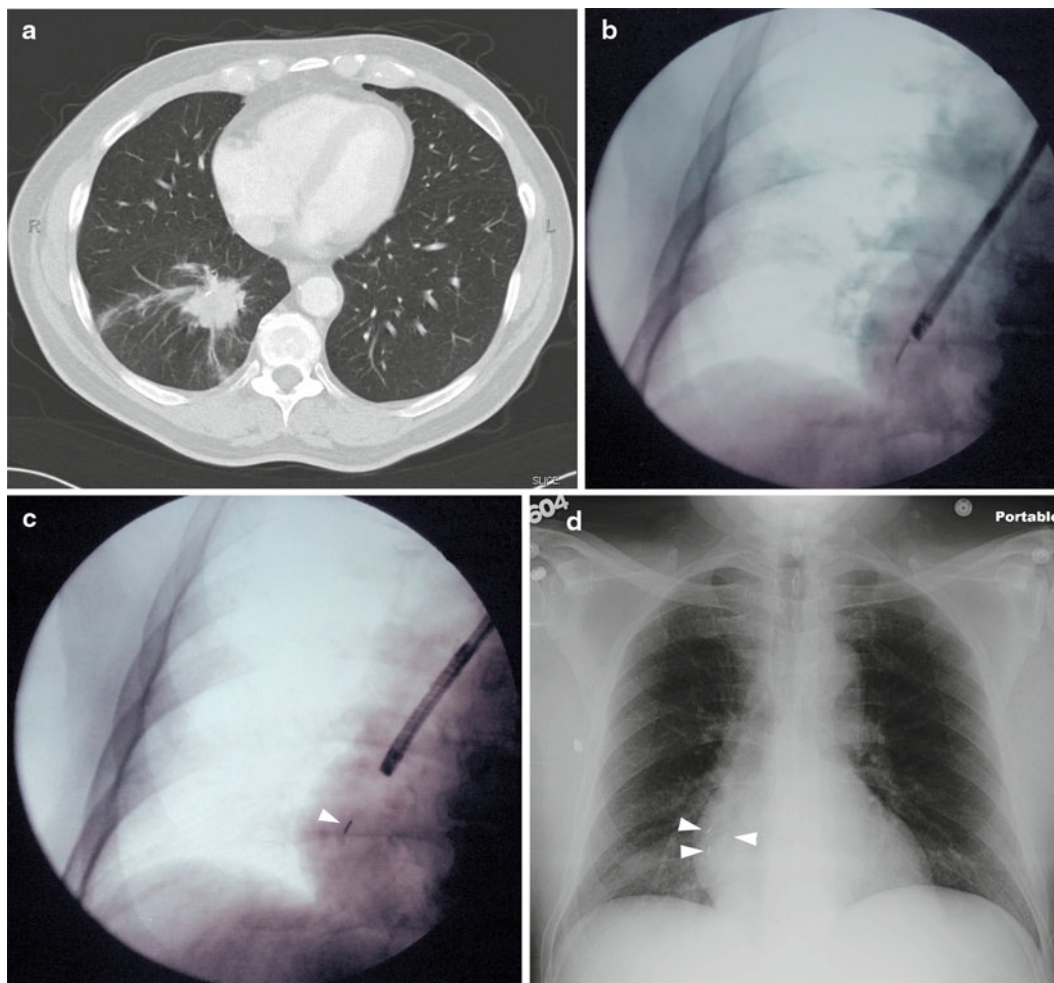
This figure demonstrates bronchoscopic implantation of a fiducial in airways in and around a tumor target. *Panel A* shows cross-sectional CT image of the tumor target. *Panel B* shows a posterior-anterior fluoroscopic image of a microbiology brush catheter (NA-201SX-4022, Olympus America, Inc., Center Valley, PA, USA) preloaded with a 0.75 mm coiled wire fiducial being passed through a
